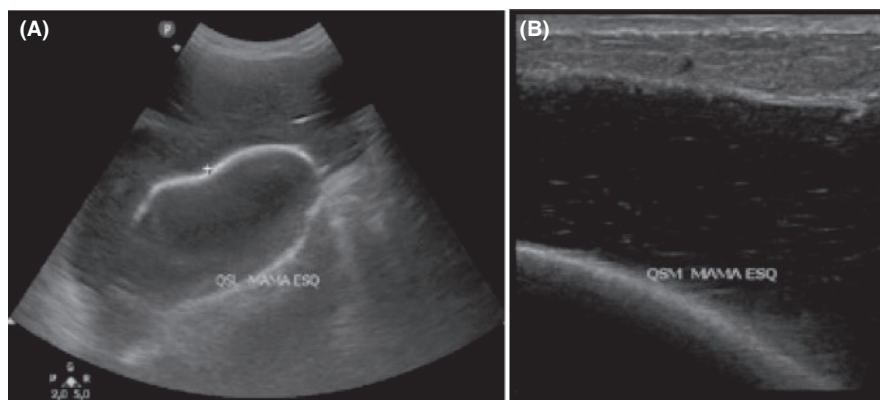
Ultrasound convex probe (A) and axial probe (B). Intracapsular heterogeneous collection compresses the breast implant on the left breast (late seroma)
